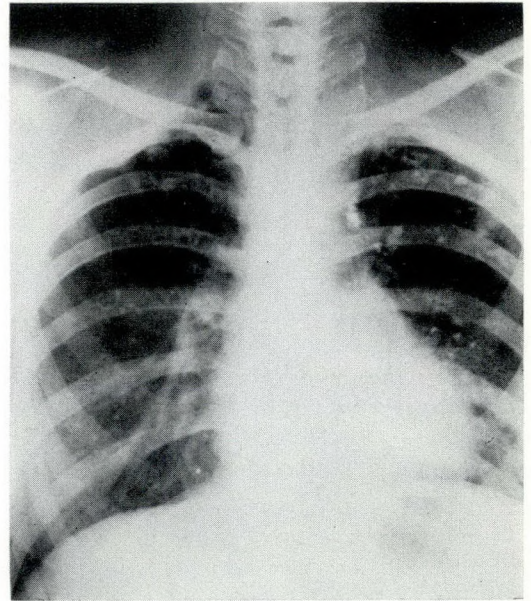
E.K. Chest radiograph January 18, 1957. Bilateral, four-rib, Semb thoracoplasty with apicolysis, done in 1949, closed the apical cavities.
